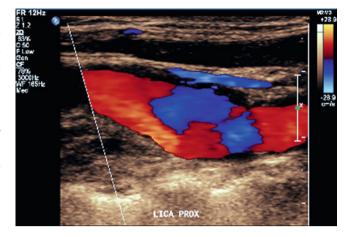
Color duplex ultrasound of the internal carotid artery: notice boundary separation zone (*blue color*)
